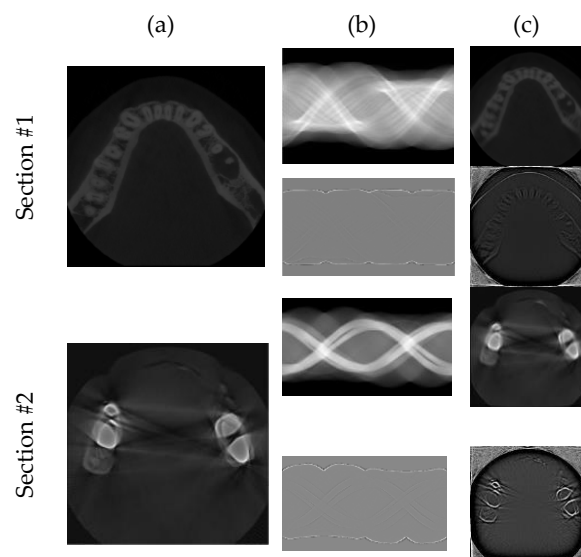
Effects of metal artifacts on the illumination and reflectance components: (a) two CT sections; (b) from top to bottom respectively, the corresponding illumination and reflectance components in the sinogram domain; (c) from top to bottom respectively, the results of projecting the illumination and reflectance components back to the spatial domain.
